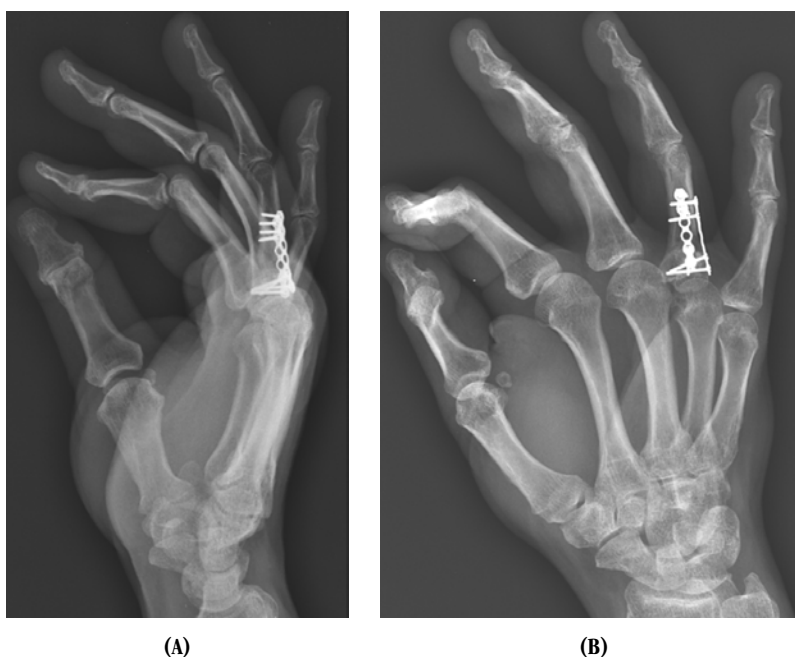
(A) Lateral and (B) oblique radiographs of the healed proximal phalanx with maintenance of good alignment.
